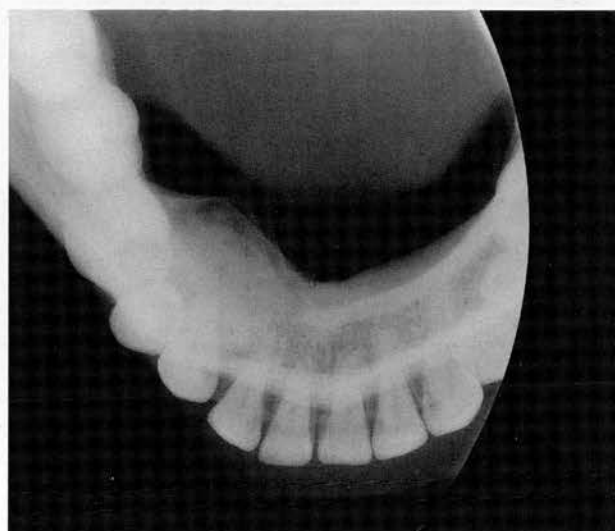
(Case 7). A true occlusal radiograph showing that the irregular central opacity seen in Figure 2 is associated with substantial expansion of the lingual plate which has been significantly thinned. Similar changes can be seen in the buccal plate. The apex of the first premolar has been displaced buccally
